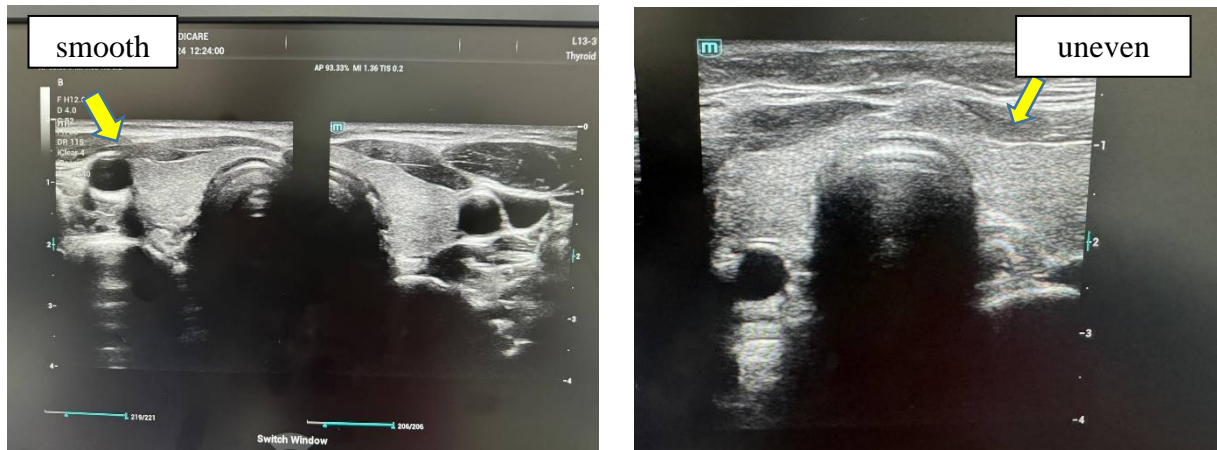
View of the thyroid gland contours during ultrasound examination
